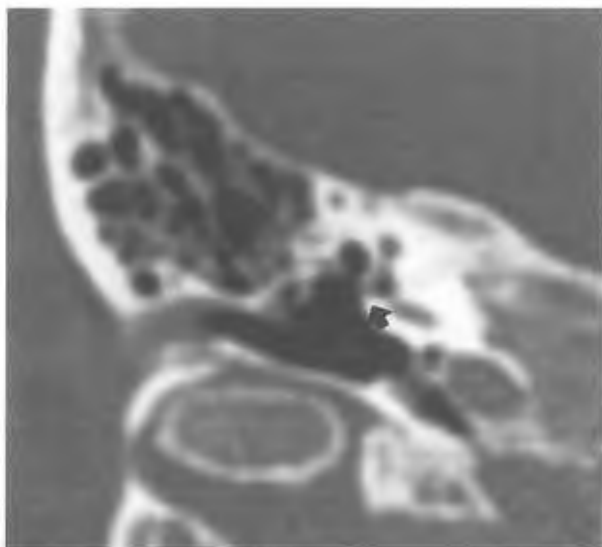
Axial CT-scan (right ear, patient 3) showing a normal round window covered by a bony plate (arrow).
